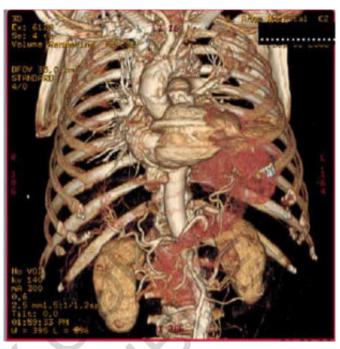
Three-dimensional VR CT image frontal view shows the endoprosthesis and the large pseudoaneurysmal sac at 3 months, demonstrated occlusion of the pseudoaneurysm with complete resolution of the endoleak.
